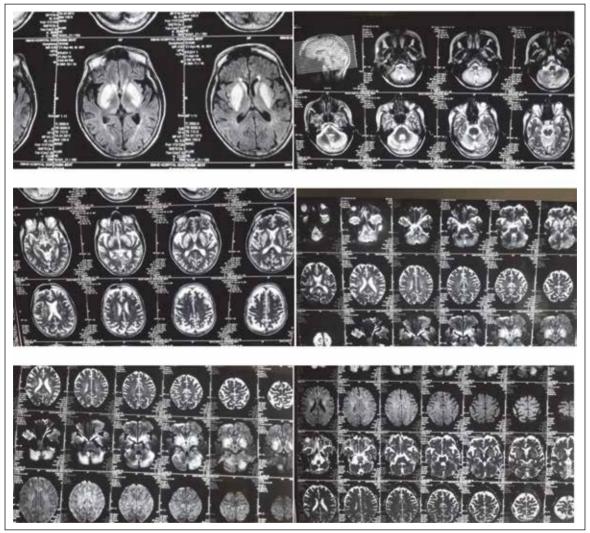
MRI brain (T2W & FLAIR images) depicting bilateral basal ganglia & cerebellar hyperintensities.
